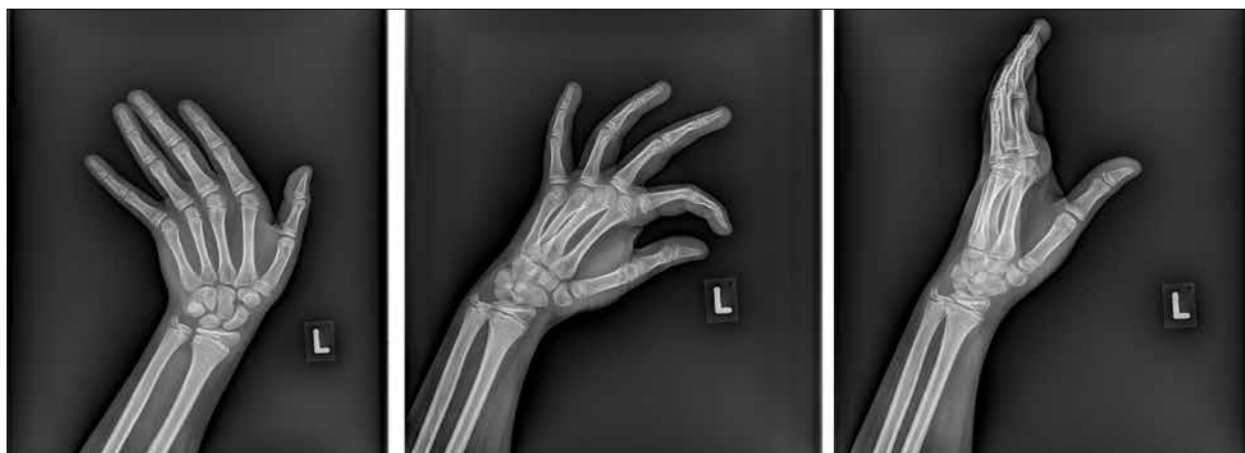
Initial radiographic presentation: X-ray clearly shows the pisiform bone dislocation
